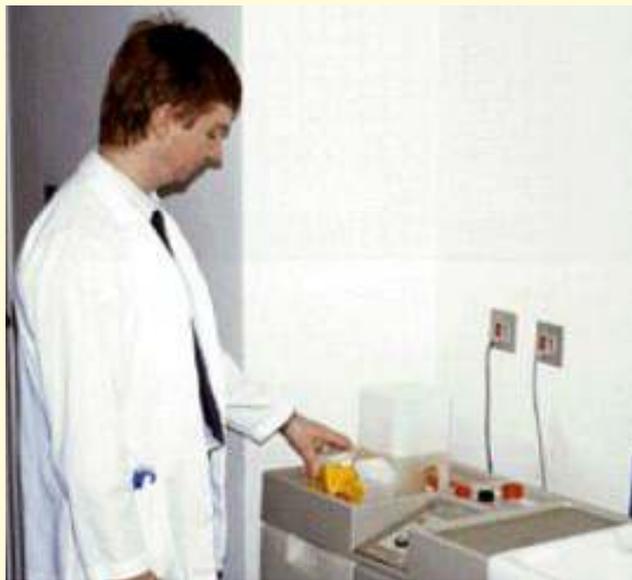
(a) Radiographer on the X-ray machine (b) Local exhaust ventilation to remove gases and vapors.
